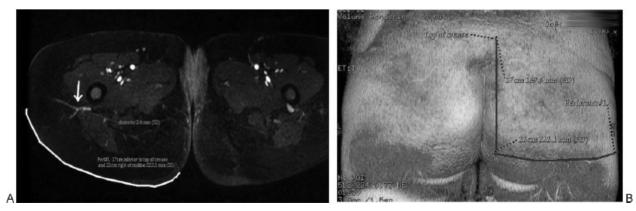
(A) Magnetic resonance imaging angiography (MRA; axial view) demonstrating a branch of the right deep femoral artery traveling around the right gluteus maximus muscle (septocutaneous vessel). (B) MRA three-dimensional reconstructed image demonstrating the location of the septocutaneous vessel in relation to the skin surface anatomy of the buttock.
